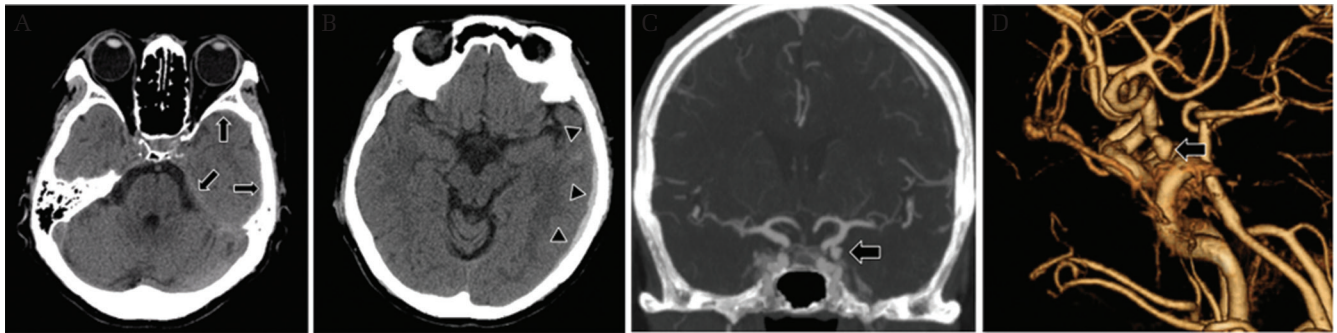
Computed tomography (CT) scans showing acute subdural hematoma tomography (ASDH) along the tentorium (*arrows*) and the convexity (*arrow heads*) on the left side (A), but no evidence of subarachnoid hemorrhage (SAH) or intracerebral hemorrhage (ICH) (B). Three-dimensional CT angiography (3DCTA) on admission demonstrates a left internal carotid-posterior communicating artery (ICA-PcomA) aneurysm projecting inferiorly (C; multiplanar reconstruction). The aneurysm is located near the temporal base and has a small bleb in the lateral aspect of the sac (D; volume rendering image).
